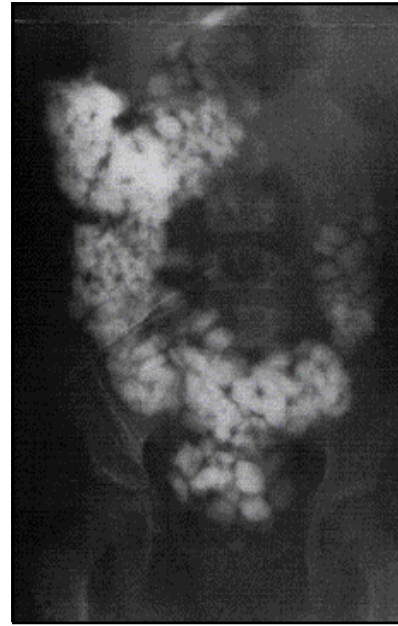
Plain x-ray of the abdomen showing multiple stones.
